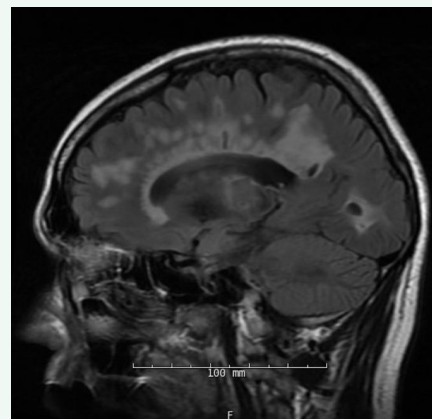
Sagittal FLAIR MRI demonstrating prominent periventricular lesions.
